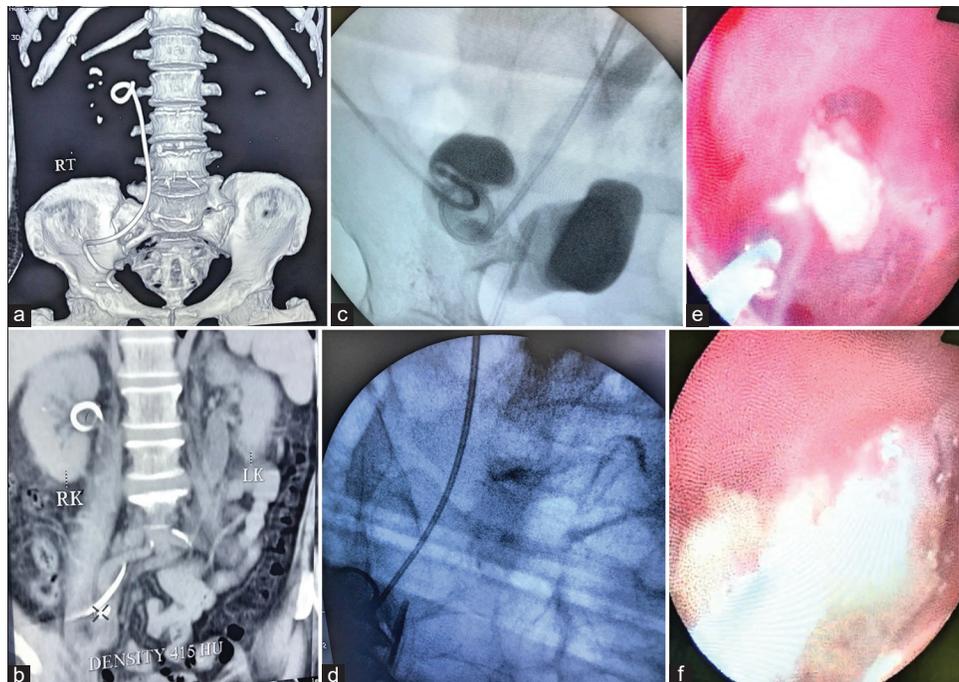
CT KUB, Pouchogram, Endoscopic view of RIRS
